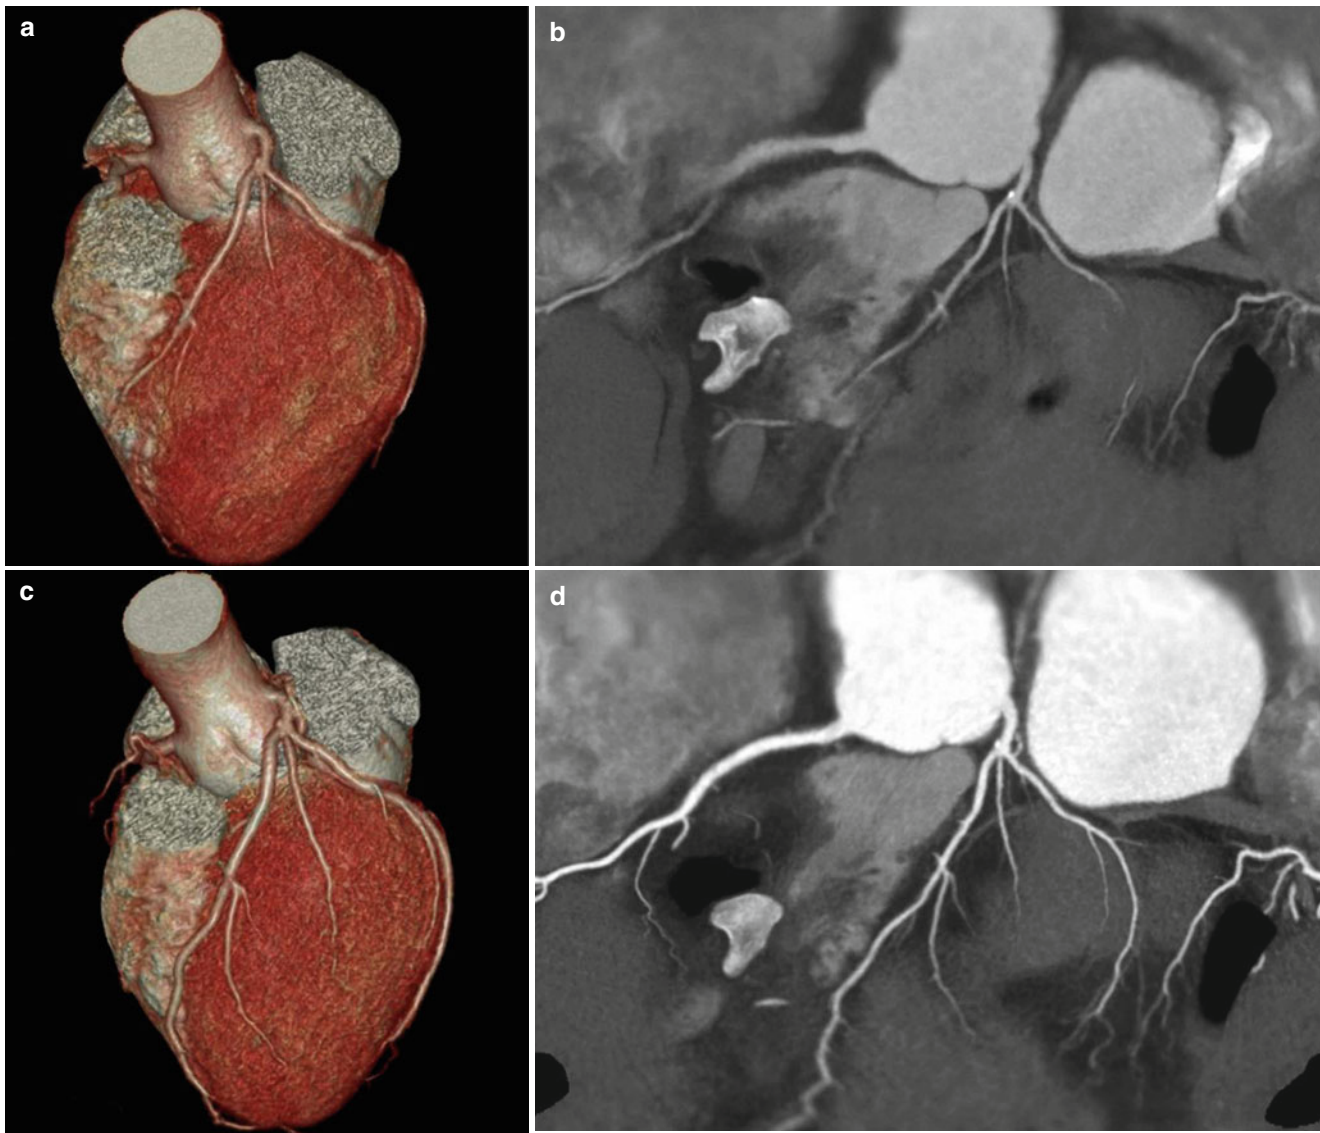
Effect of nitroglycerin (NTG). (a, b) A 54-year-old female underwent an initial coronary CTA without NTG administration. The VRT and 2-D map view could not fully reveal the branches of the coronary arteries. (c, d) The same patient underwent a second coronary CTA
